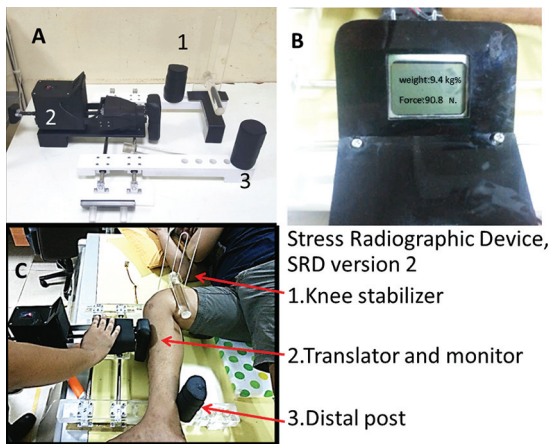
The Stress Radiographic Device (SRD), version 2. (A) The SRD with body, knee stabilizer (proximal post), distal post, translator and (B) monitor. (C) The SRD and the translator are applied with a 90-newton force posterior translation on the anterior surface of the tibia and 10 cm below the joint line.
